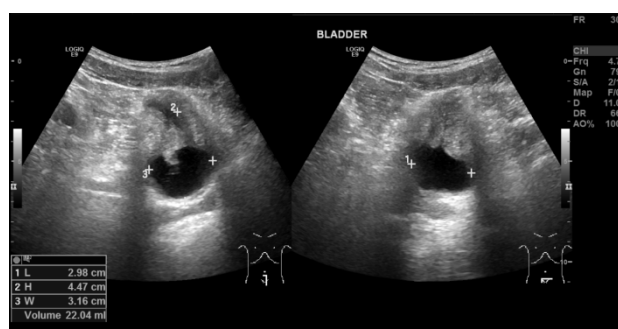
Ultrasound demonstrates thickened urinary bladder wall and reduced bladder capacity
